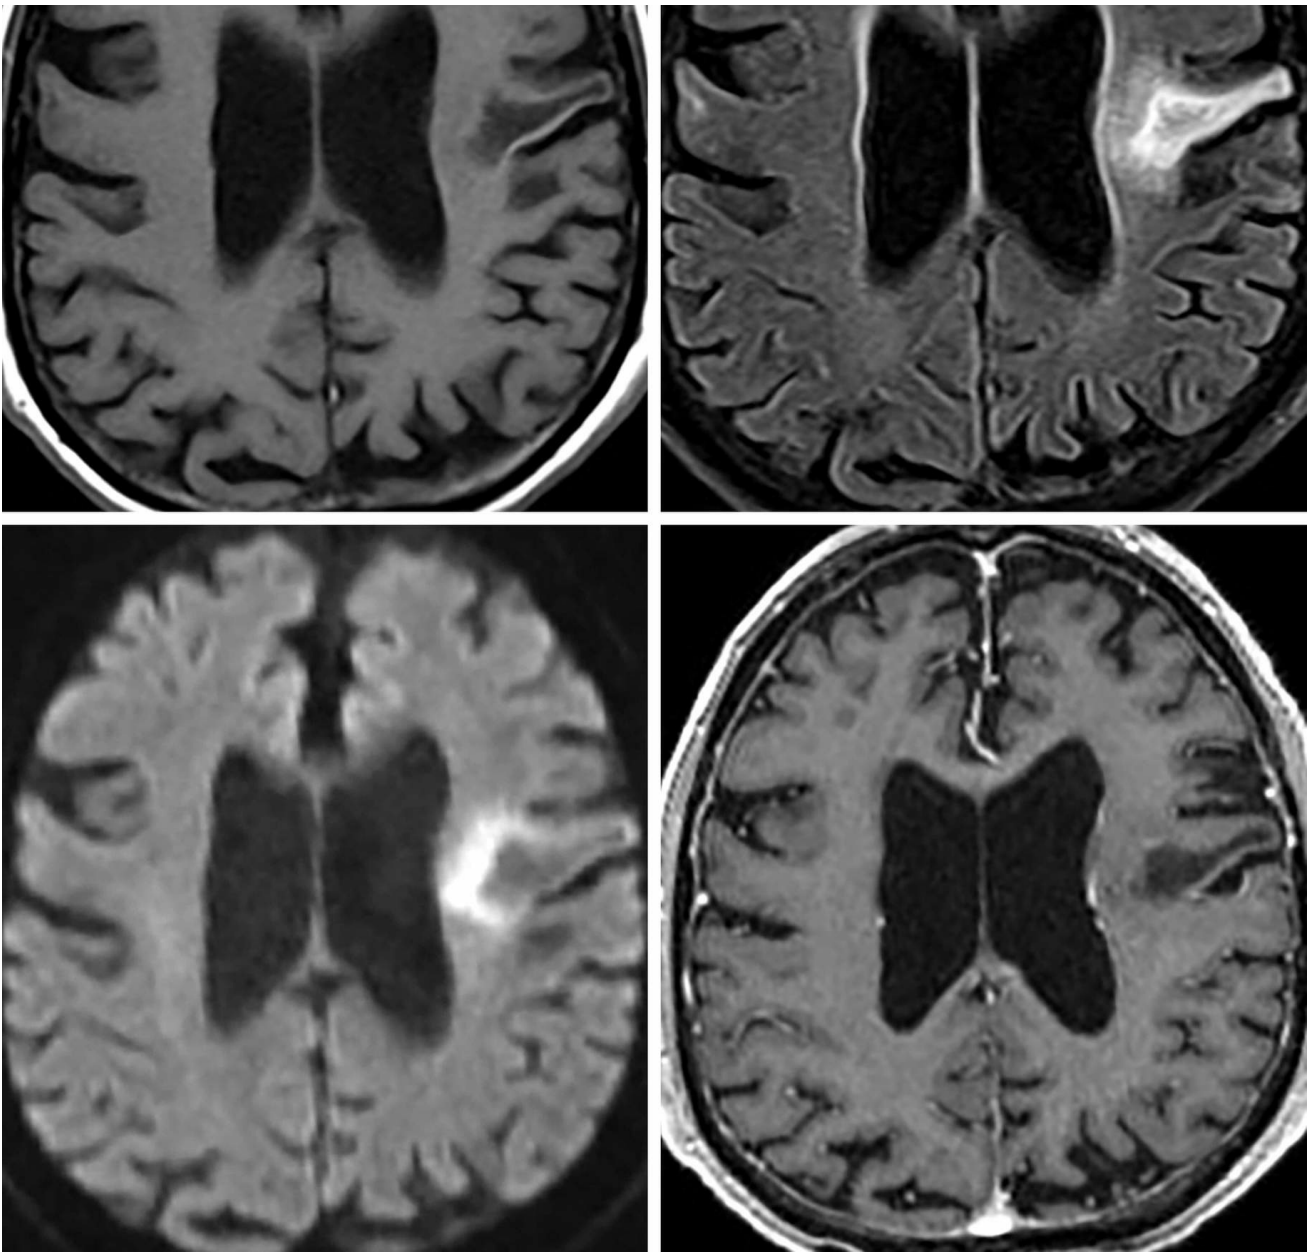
Initial imaging of a patient with AIDS demonstrates a linear, T1-hypointense (top left), FLAIR-hyperintense (top right) region within the subcortical white matter of the left dorsolateral frontal lobe with associated volume loss. There was minimal associated peripheral reduced diffusivity (second row left) and no significant contrast enhancement (second row right). Little was known about the patient at presentation to the emergency department, and given the patient's recent onset of symptoms, a diagnosis of subacute infarction was made. Follow-up examinations over the next several months demonstrated a significant interval increase in T1-hypointense (third row left), FLAIR-hyperintense (third row right) signal abnormality within the subcortical white matter extending to the lateral ventricle. The degree of adjacent reduced diffusivity continued to increase in size. (Bottom Left) Postcontrast imaging does not show abnormal enhancement. The continued increase
